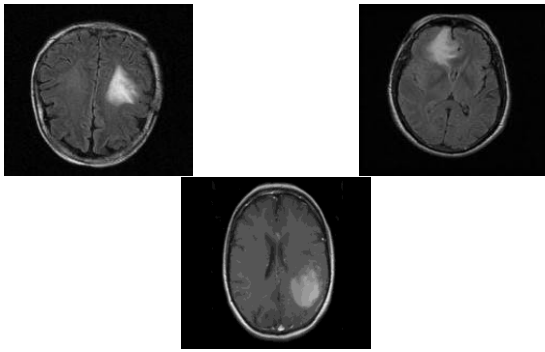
Comparative visualization of three brain tumor types in MRI imaging.
